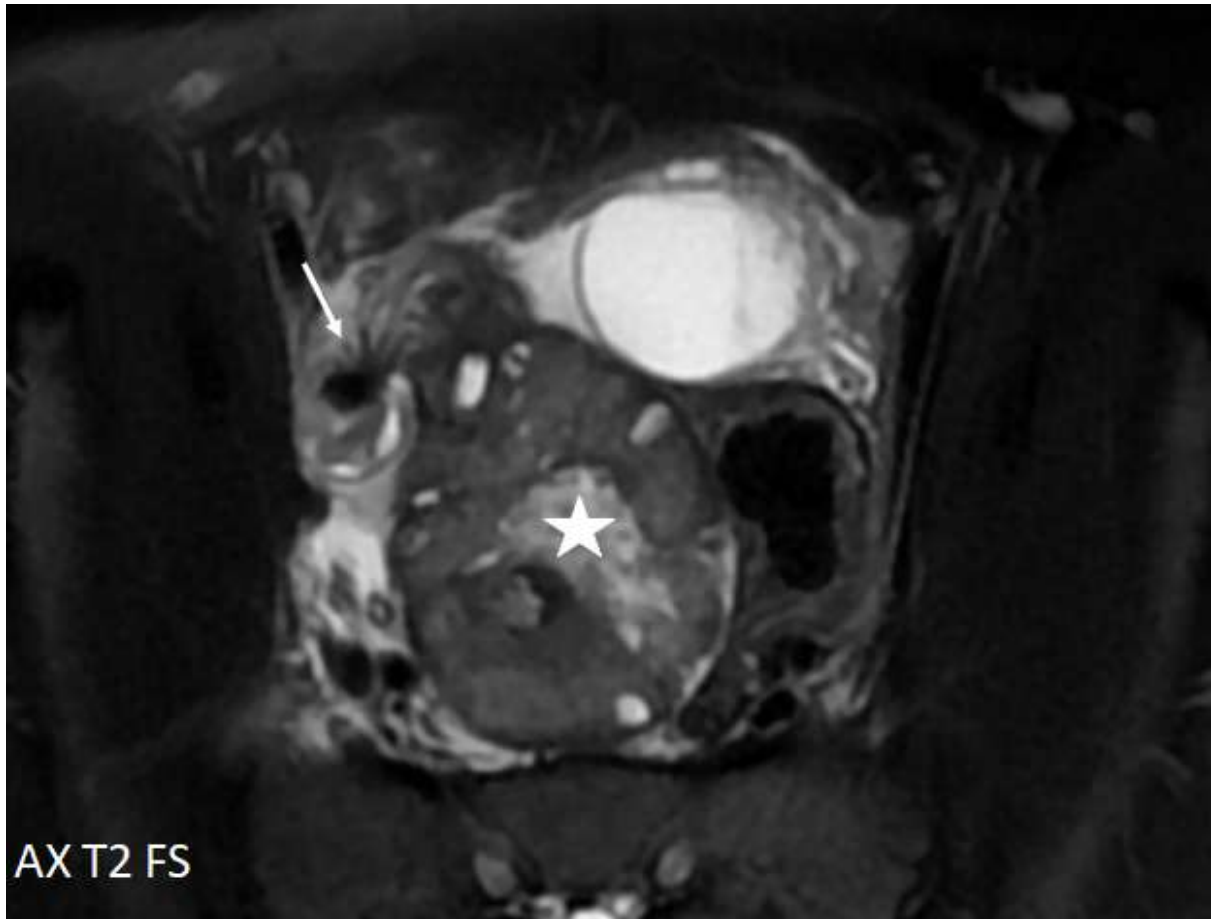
Pelvic MRI showing a whirpool sign (arrow), enlarged right ovary, ovarian stromal edema (star) and peripheral arrangement of follicles.
